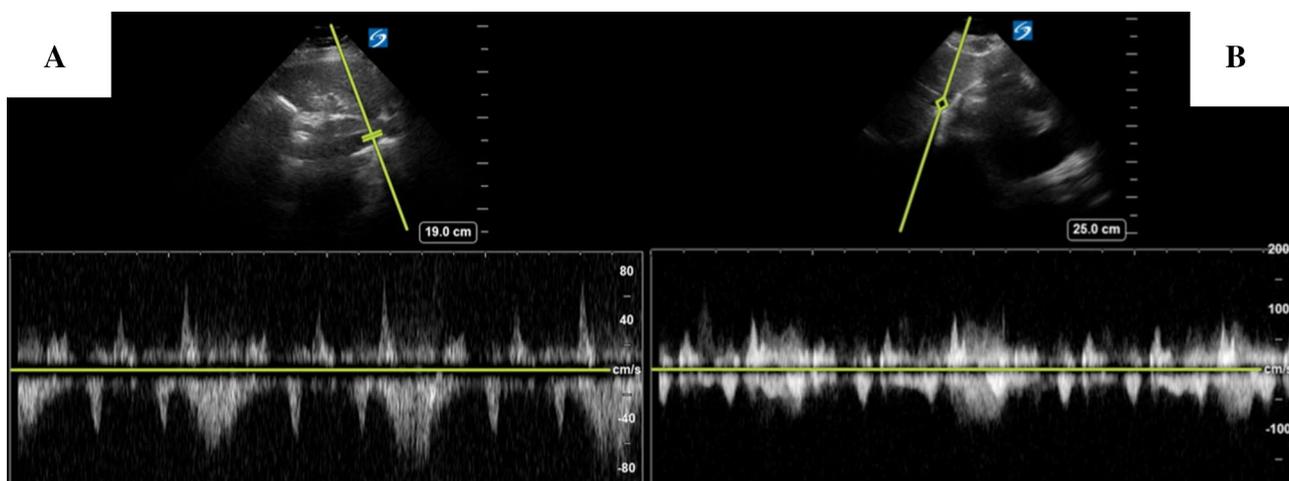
Bedside ultrasound of the IVC long axis view with application of doppler at the junction of the IVC/right atrium (a) and the hepatic veins (b) demonstrating reversal of flow in both regions
